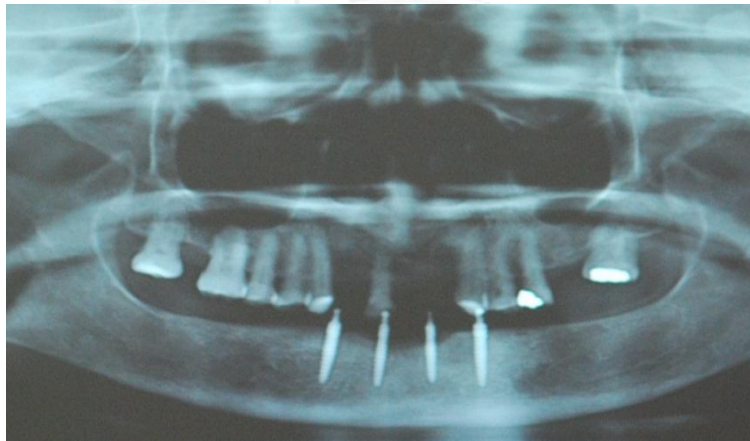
Figure C The Radiographic examination in 1 month after loading L-CD, noticed the progressive marginal bone loss on the MDIs area #31 and #41
